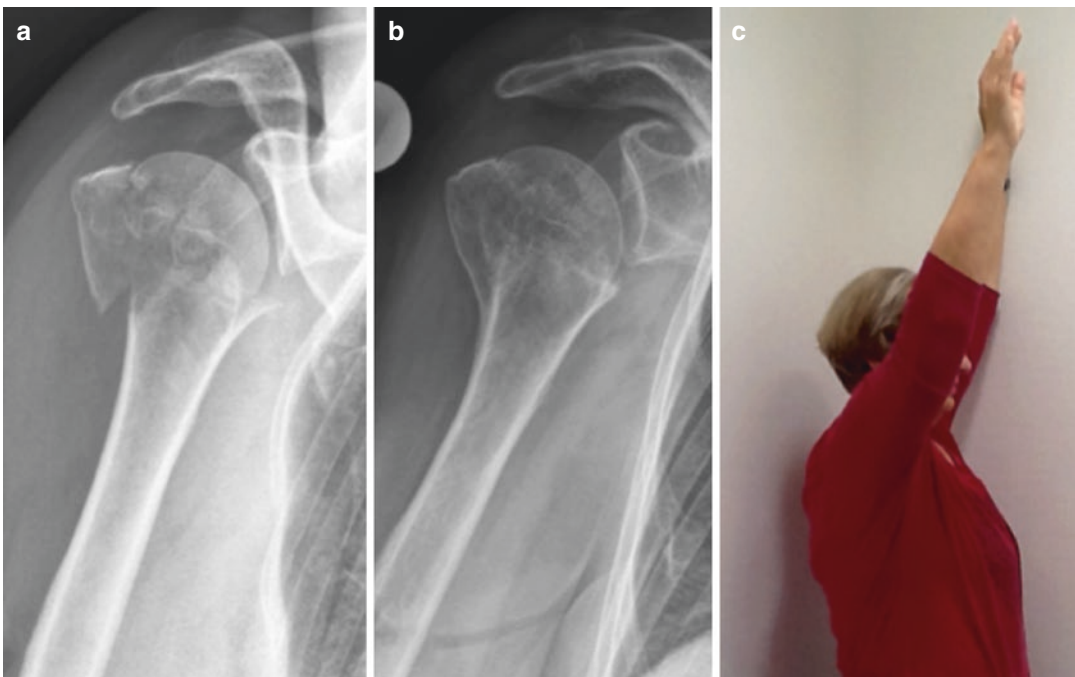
(a) AP radiograph of a valgus impacted 2-part fracture of a 69 y.o. female. (b) AP radiographic follow-up after 1 year. (c) Clinical result (forward flexion) after 1 year
